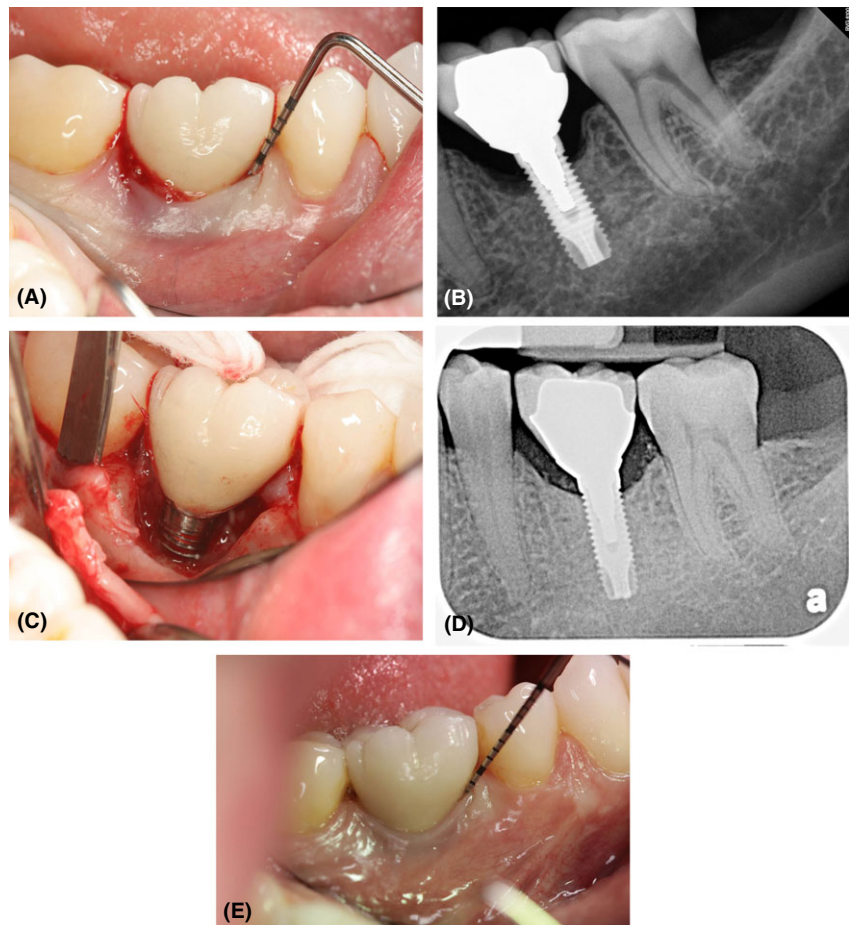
Treatment of Peri-implantitis utilizing a combination therapy approach with EMD. (A) A 41-year-old, healthy female presented with peri-implantitis around implant #19i characterized by bleeding on probing, 8 mm probing depths and loss of bone. (B) Pre-surgical X-ray indicating bone loss. (C) Flap reflection prior to surface decontamination showing 7 mm of interproximal bone loss on the mesial and distal aspects of the implant. (D) Radiograph 4 years following treatment showing fill of the defect. (E) Clinical photo, 4 year post-op, showing the deepest probing depth of 3 mm with a complete absence of bleeding on probing.
